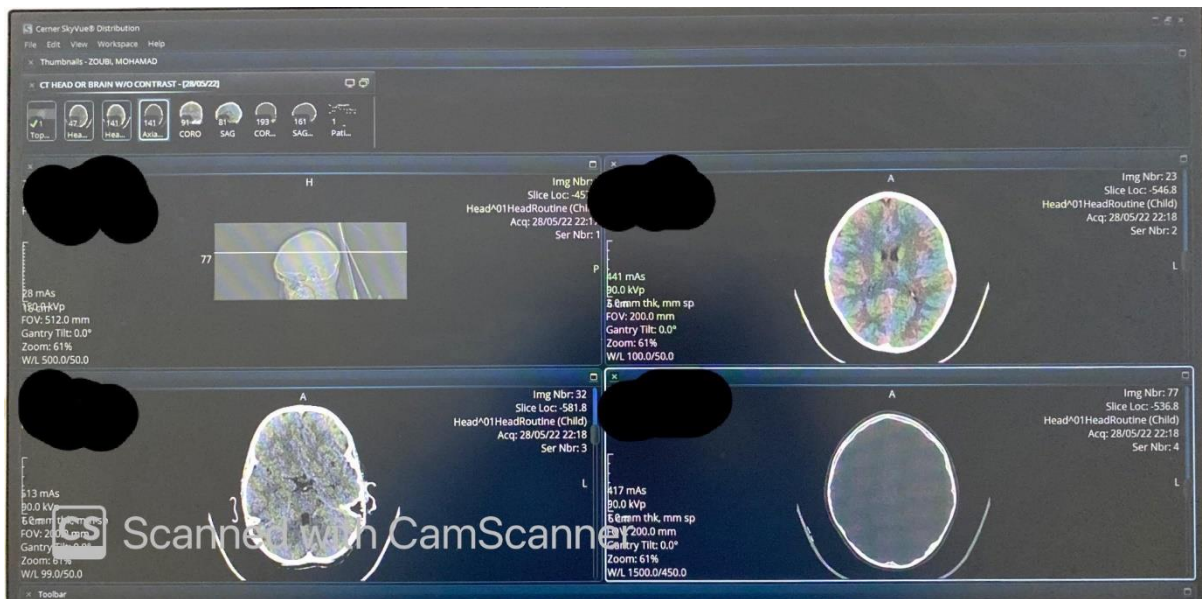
(A): CT Head was done and shows Normal appearance of the brain parenchyma without focal lesion.
